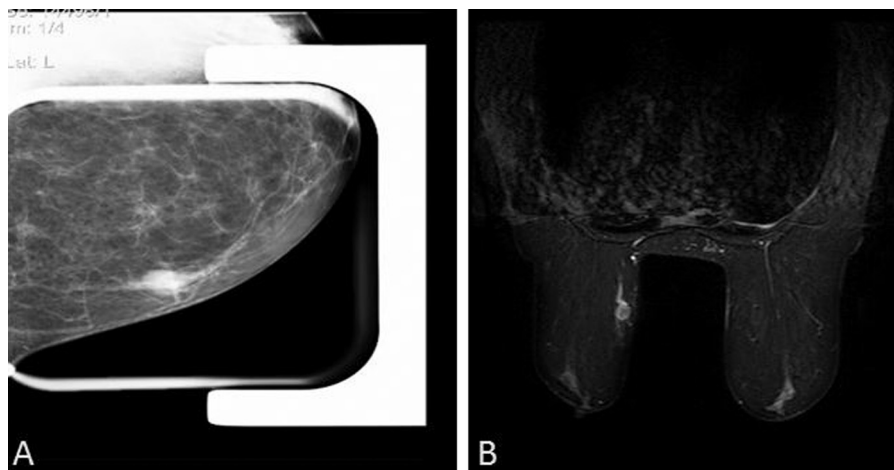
Panel A: Diagnostic mammogram of left breast cranio-caudal view identified a new onset dominant mass in the left upper inner quadrant (BI-RADS 4) Panel B: short T1 inversion recovery MR images of B/L breast demonstrates suppressed normal breast adiposity in both breasts and a dominant mass with high signal intensity that corresponds to lymphoma.
